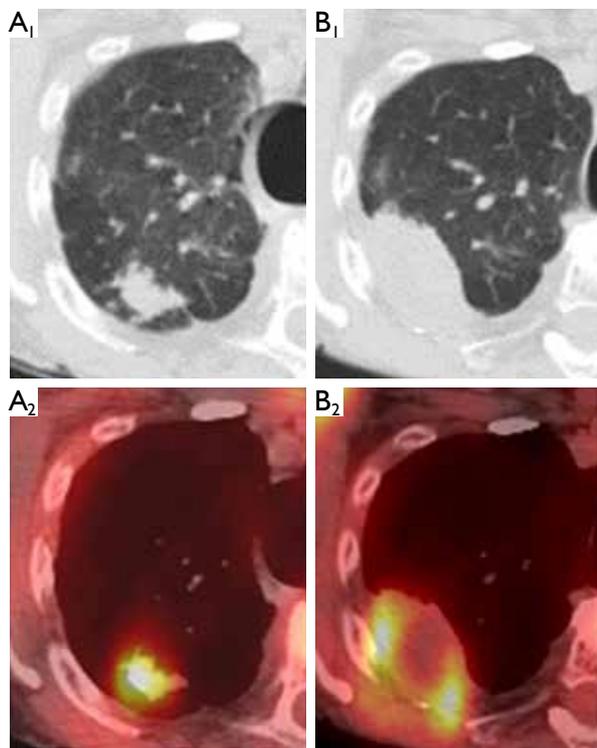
(A₁,A₂) Axial CT (A₁) and fused PET/CT (A₂) images show a right upper lobe nodule demonstrating intense metabolic activity; (B₁,B₂) Axial CT (B₁) and fused PET/CT (B₂) images 3 months after microwave ablation show a consolidation with rim FDG uptake, which are normal findings secondary to inflammation
